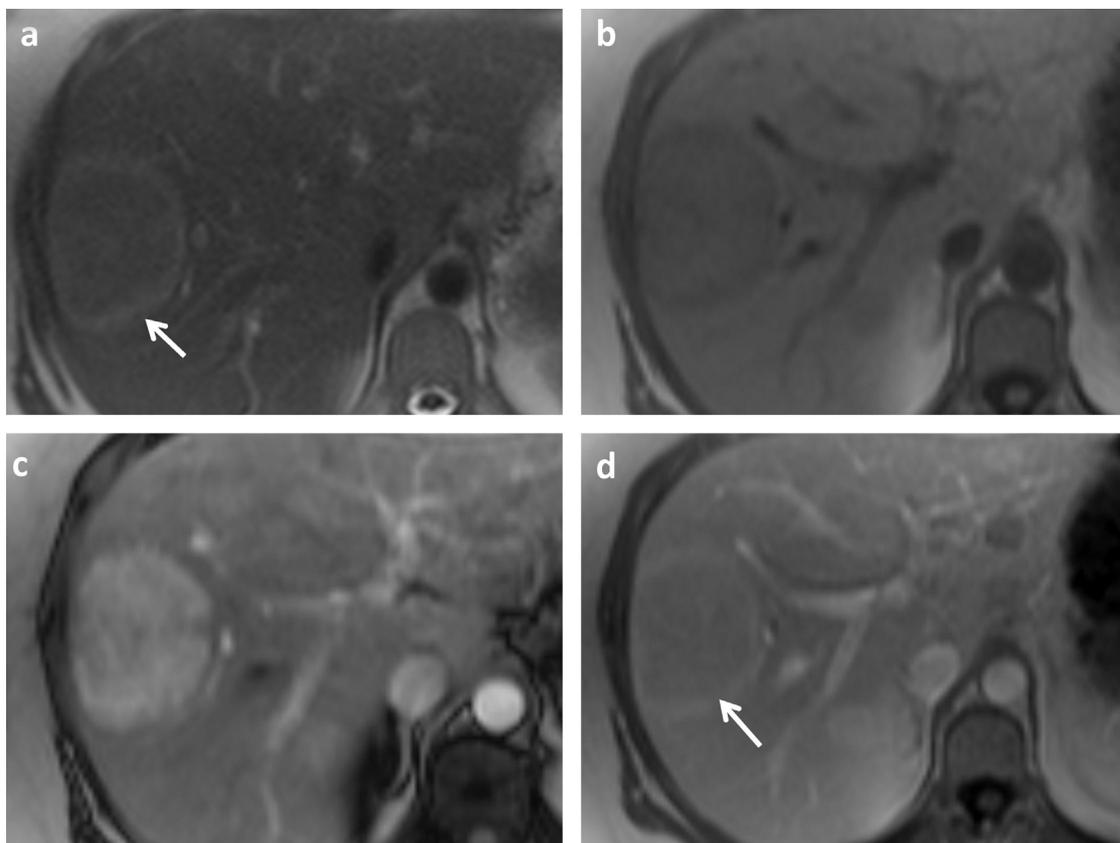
MRI nodule N2 (IHCA); a: T2 weighted imaging : the lesion presents T2 hyperintense signal band in periphery (black arrow) with center isointense to surrounding liver (typical atoll sign); b: T1 weighted imaging : the lesion appears isointense to surrounding liver whereas the peripheral band is slightly hypo intense; c: Arterial phase shows a strong and homogenous arterial enhancement after gadolinium intravenous administration; d: at portal venous phase, the center of the lesion is isointense to surrounding liver whereas the peripheral band remains hyperintense corresponding to sinusoidal distension (black arrow).
